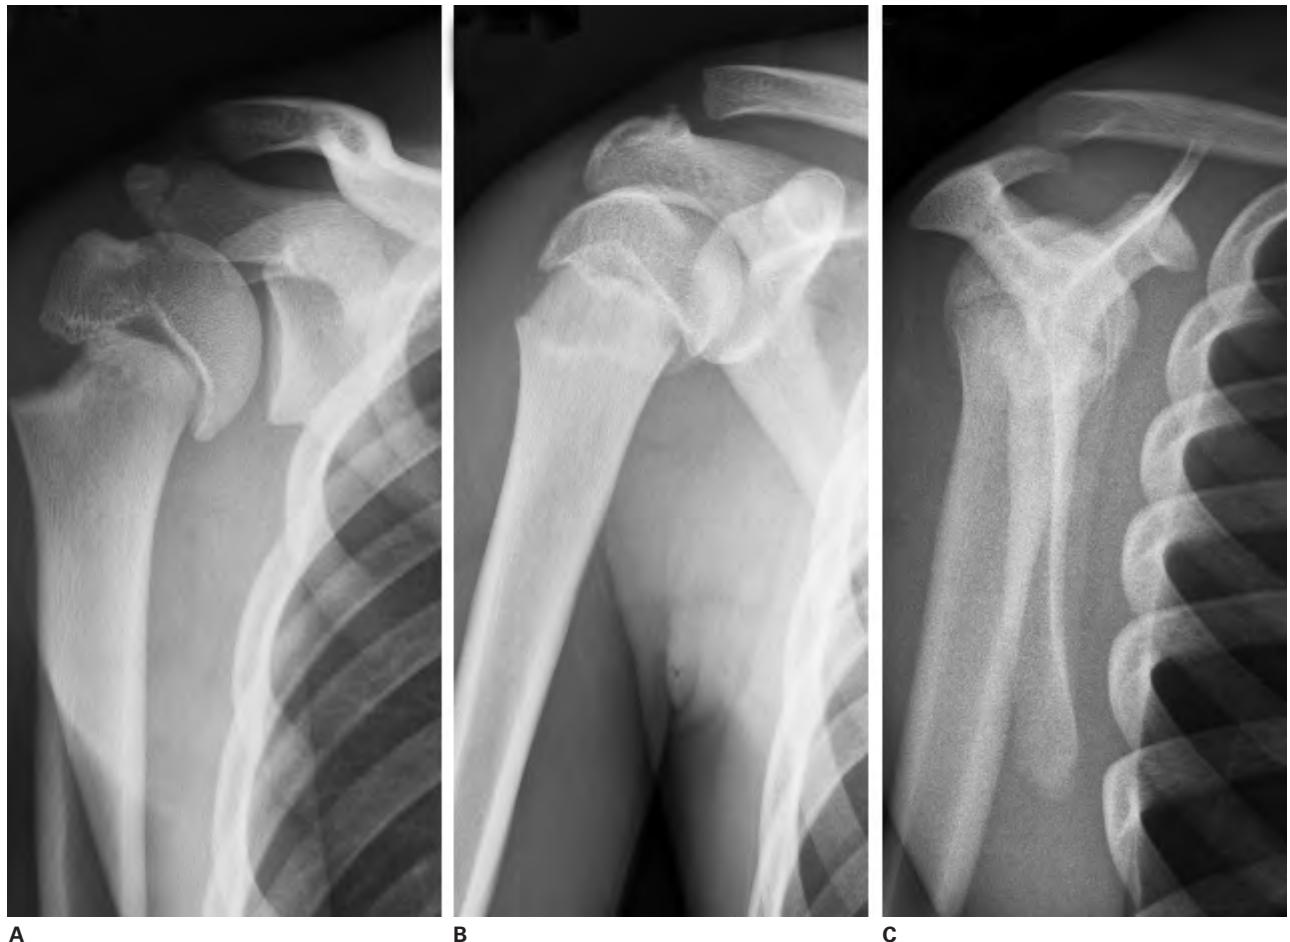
Anteroposterior in the scapular plane (A), anteroposterior (B), and scapular-Y (C) radiographic views of the right shoulder demonstrating a displaced Salter-Harris I fracture of the proximal humerus.
